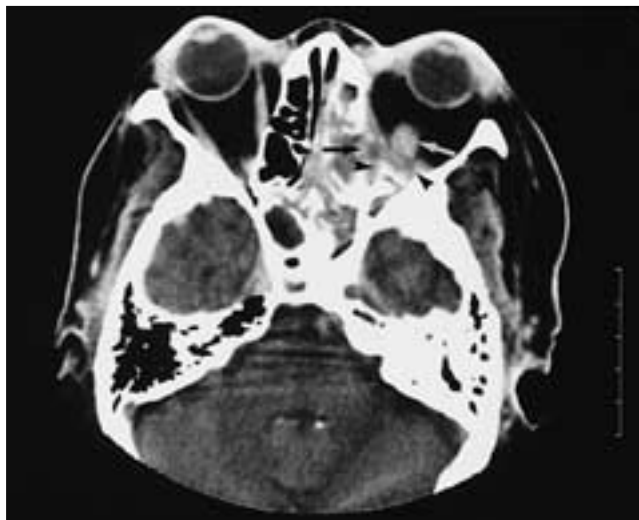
Orbital apex infection, left. Axial contrast-enhanced CT scan obtained 1 day following surgery. Proptosis, orbital pain, and decreased motility were noted. Note the bony defect in the lateral wall of the posterior ethmoid complex (black arrow), phlegmonous changes in the apex (arrowheads), and thickening of the inferior rectus muscle (white arrow). The diffuse sinus opacification may be seen immediately after surgery.
